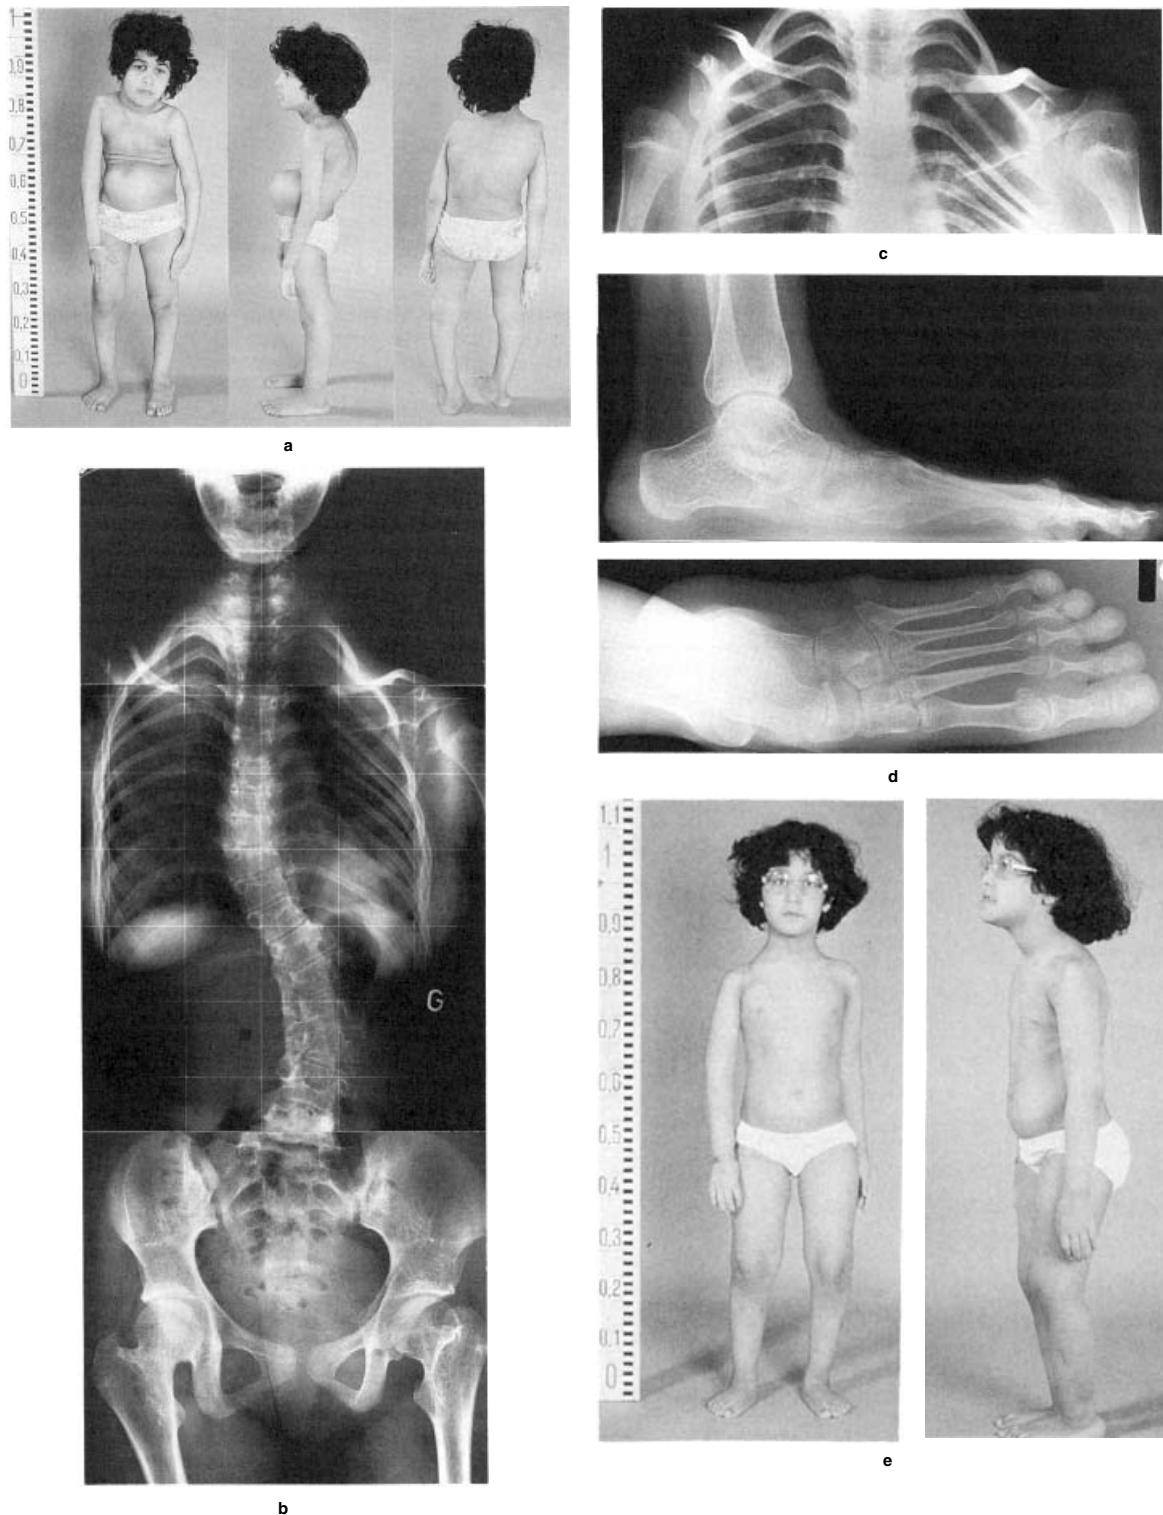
Kyphoscoliotic type of EDS (EDS VIA). H.A. (30 Jul 1976) and N.A. (31 May 1981) (cases 19 and 20 in the legend to Fig. 22) are the third and fifth children of healthy parents from Qatar who are first cousins. This family was the first in which the disorder was characterized at the molecular level [395]. (a) H.A. (5½ years old): severe kyphoscoliosis, dislocation of the right shoulder, flat feet in valgus position, microcornea. (b) X-rays of the spine 4 years after Harrington rodding and 3 years after removal of the rod because of its displacement due to premature loading (11 years). (c) X-ray of the shoulder showing dislocation of the right humerus (11 years). (d) X-ray of the foot showing marked osteoporosis and flat feet (11 years). Because of joint instability, arthrodesis of the lower ankle joint was required 2 years later. (e) N.A.: younger affected sibling who has a much milder phenotype, at age 5 years, shown for comparison, and thereby demonstrating marked intrafamilial variability. ((a), (e) reprinted from Steinmann [42] with permission.)
